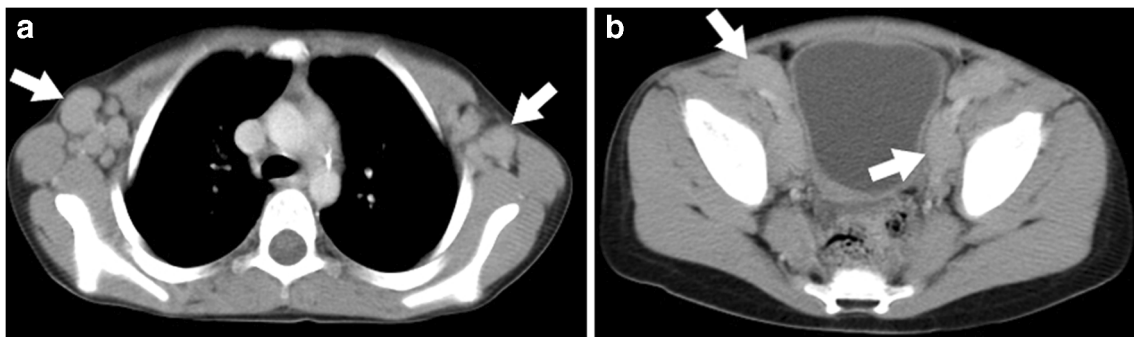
Muckle-Wells syndrome (V200 M mutation in *CIAS1* gene) in a 4-year-old girl with an 8-month history of rash, fatigue, decreased appetite and palpable enlarged lymph nodes. Axial contrast-enhanced CT images of the chest (a) and pelvis (b) show extensive bilateral axillary
